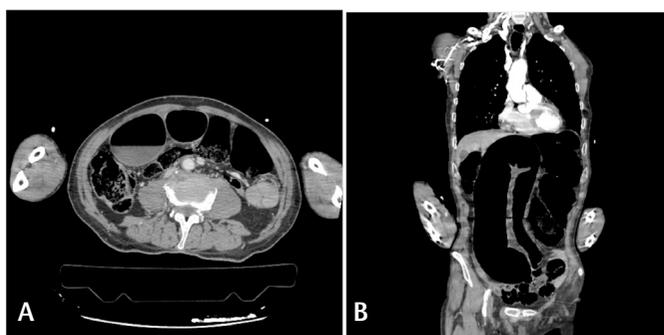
Abdominal computed tomography images. (A) Transvers plane, (B) coronal plane
